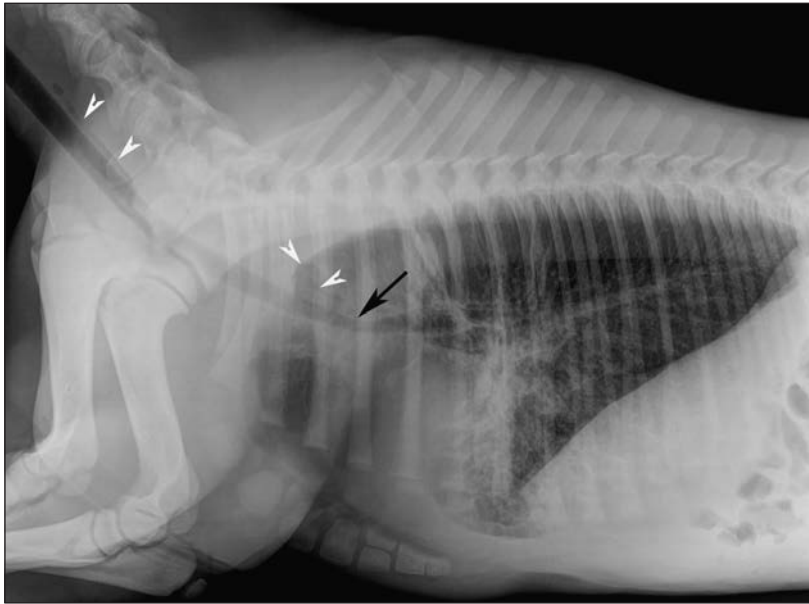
Same radiographic image as in Figure 1. A mixed bronchointerstitial-alveolar pattern is evident and is most severe in the caudoventral aspect of the lung fields. Notice the focal ventral deviation and mild narrowing (arrow) of the intrathoracic trachea at the level of the cranial aspect of the heart base. A small amount of intraluminal gas is evident in the cervical and cranial thoracic portions of the esophagus (arrowheads).
